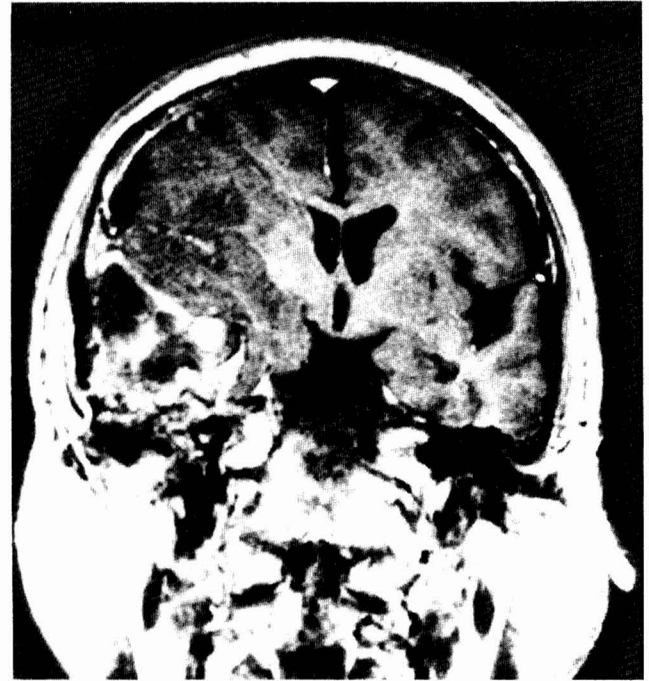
T1-weighted magnetic resonance image after intravenous administration of gadolinium diethylene-triamine-pentaacetic acid showing a mixed signal intensity mass lesion and displacement of the temporal lobe and lateral ventricle by the mass.
